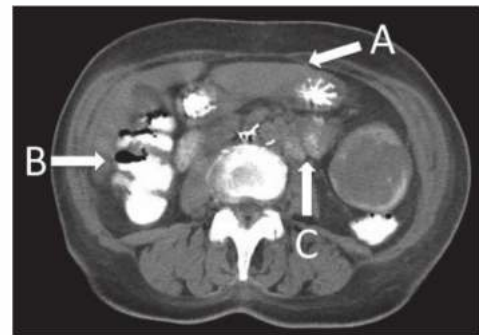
• CT scan shows a large obstructing colon cancer in the transverse colon (A) with dilation of the cecum (B) and a paucity of fluid and gas in the small bowel (C).
